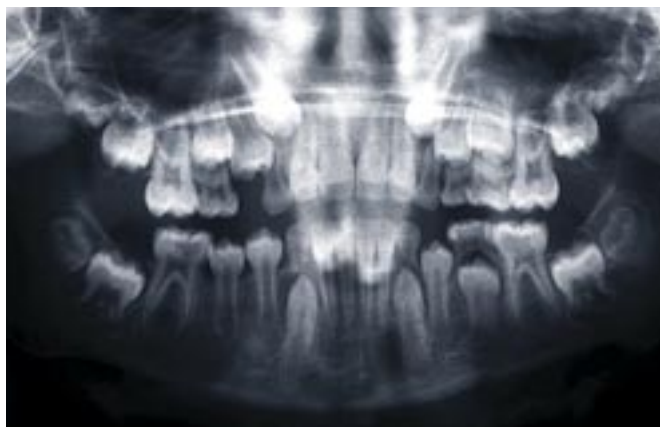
Panoramic radiograph of a patient with MIH showing extensive defects in teeth 36 and 46 occlusally. This OPG demonstrates some features that indicate the 'ideal timing' for extraction of a FPM: the bifurcation of the second molars are developing and the third molars are present.
